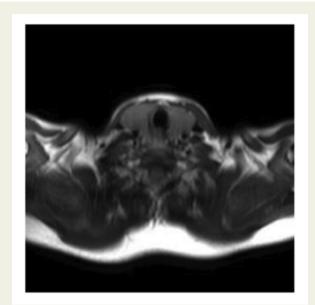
Cardiovascular magnetic resonance images on initial presentation showing enlarged thyroid gland (goitre) on black blood imaging.
